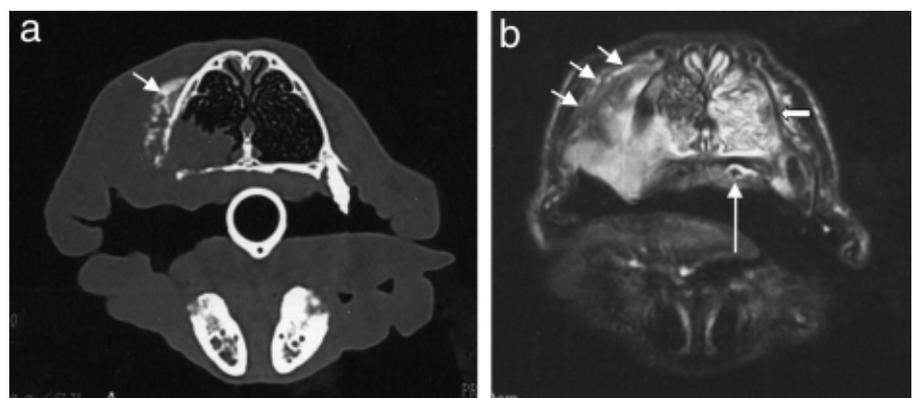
a: A computed tomographic bone window image of patient 11. Although bone destruction and extension of the tumour into the R nasal passages is clearly seen, the soft tissue margins on the buccal aspect are not well defined. Note the intra-lesional calcification (arrow) not seen on MR image (1b). Diagnosis: squamous cell carcinoma.
